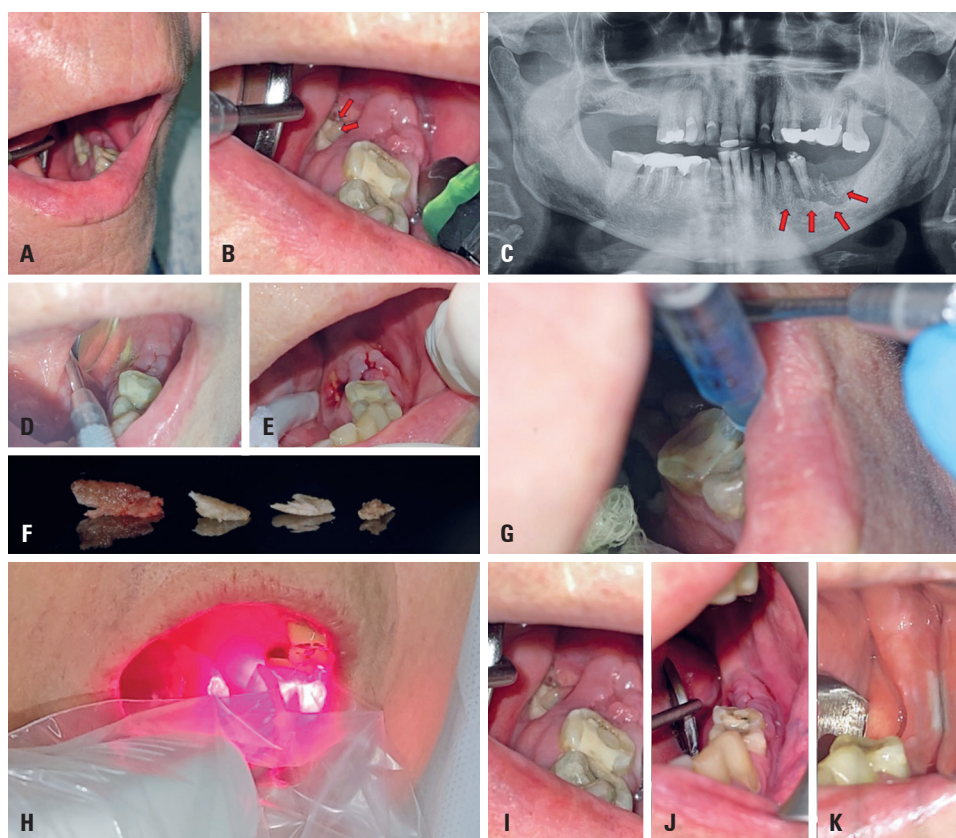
A) Clinical view, B) close-up view, and C) radiographic view of stage 3 medication-related osteonecrosis of the jaw affecting the left mandible before sequestrectomy; D) removal of the necrotic bone using piezoelectric bone surgery; E) surgical site after removal of the necrotic bone; F) removed bone fragments; G) before antimicrobial photodynamic therapy, 4mL of 100µg/mL methylene blue was applied for 1 min as a pre-irradiation step. H) Application of 660-nm red light to the posterior region of the right mandible (100mW; 6J/point); comparison of the treated area at I) baseline, J) 7 days after photodynamic therapy, and K) 60 days after treatment. Note the complete closure of the area
